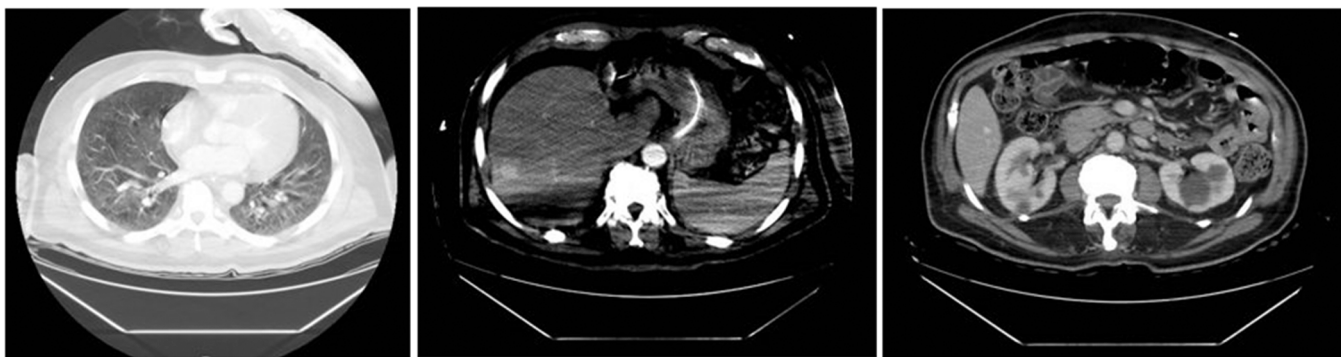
CT chest, abdomen, and pelvis with IV contrast shows bilateral patchy ground-glass opacities, a large area of ill-defined hyperdensity in the right lobe of the liver, bilateral renal cortical cysts, and retroperitoneal lymphadenopathy.
